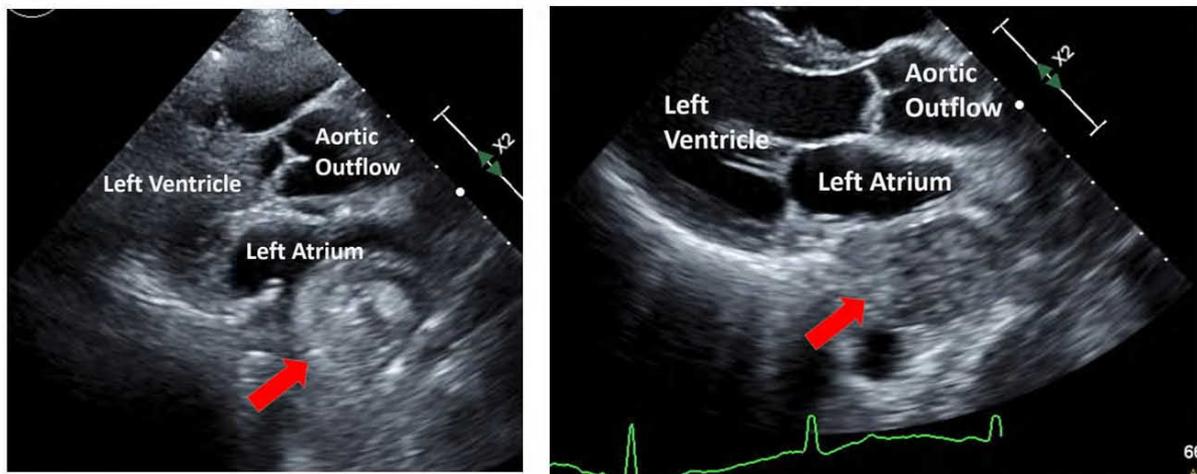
Echocardiographic images of the extracardiac mass (depicted by the red arrows) before (left) and after (right) the patient was given liquid to drink, with a change in echo density seen.
